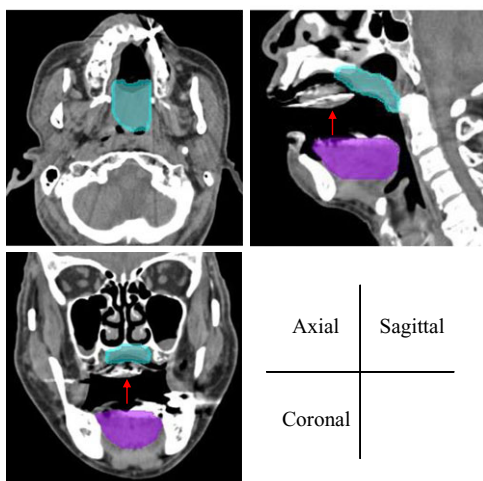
Three cross-sections (axial, sagittal and coronal) of the high-risk clinical target volume (HR-CTV; light blue) and organ-at-risk (OAR; purple) ROIs. The red arrows indicate the mold. High computed tomography values in the mold indicate catheters for transporting ^{192}Ir sources.
